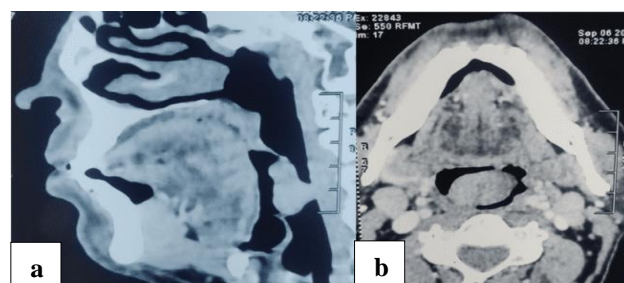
Contrast enhanced computed tomography shows homogenously enhancing mass arising from uvula hanging in oropharynx, (a) sagittal view and (b) coronal view.
